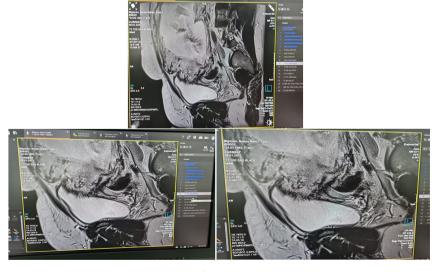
Ultrasound scans and MRT of patient.
